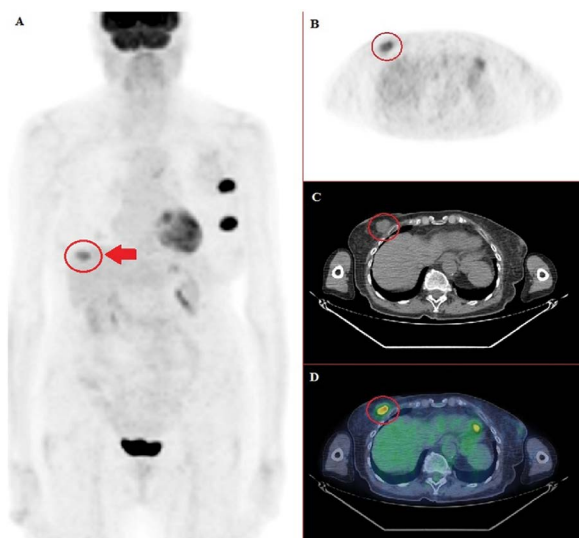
Maximum Intensity Projection (MIP) (A), axial PET (B), axial CT (C) and fused PET-CT in FRENCH color (D) images of a PET-CT scan reporting bilateral breast lesions (right lesion labeled by red circle and arrow) and left axillary metastasis
